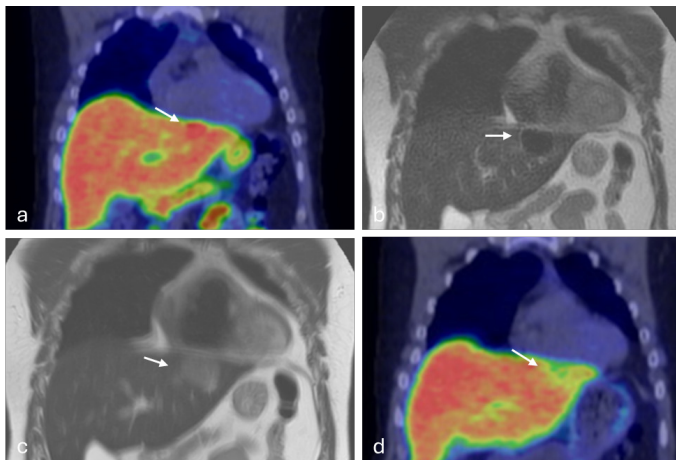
85-year-old male with prostate cancer metastasis in the subdiaphragmatic left hepatic lobe, 5 mm from the cardiac silhouette. (a) Pre-procedural coronal PET/CT demonstrating an FDG-avid lesion (arrow) inferior to the cardiac border. (b) Coronal T2-weighted MRI showing the lesion (arrow) immediately beneath the diaphragm. (c) Immediate post-ablation axial T2-weighted MRI demonstrating the signal-void iceball (arrow) with a preserved T2 interface between the ablation zone. (d) Follow-up coronal PET/CT demonstrating complete metabolic response (arrow) with no in-field local tumor progression.
